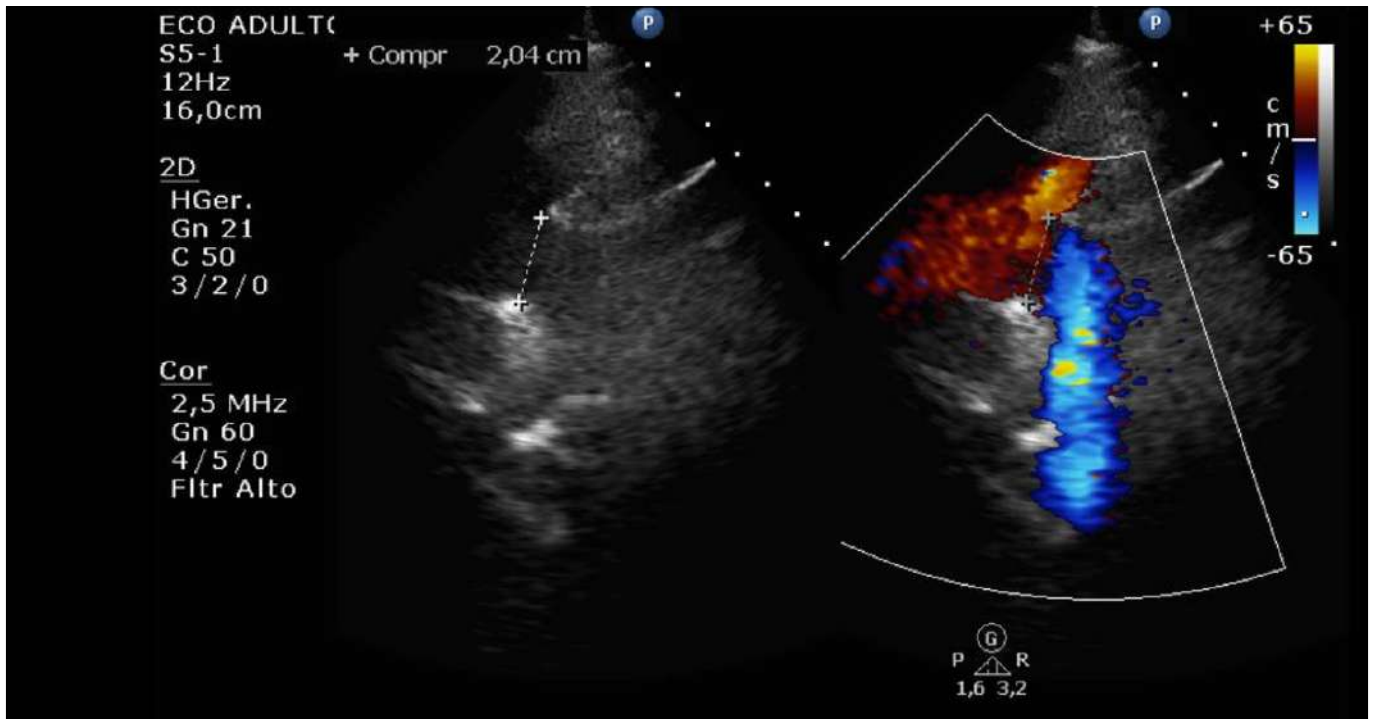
Bi-dimensional echocardiogram with N-flow mapping after explantation of CentriMag device, showing preserved bi-ventricular function (July 16, 2019).
